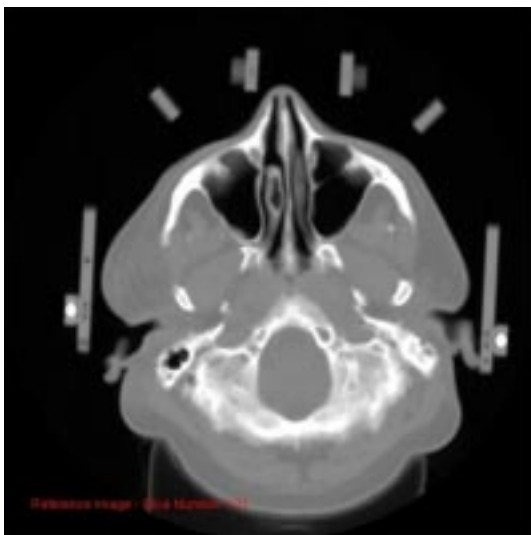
CT slice with two markers (the white circles)
